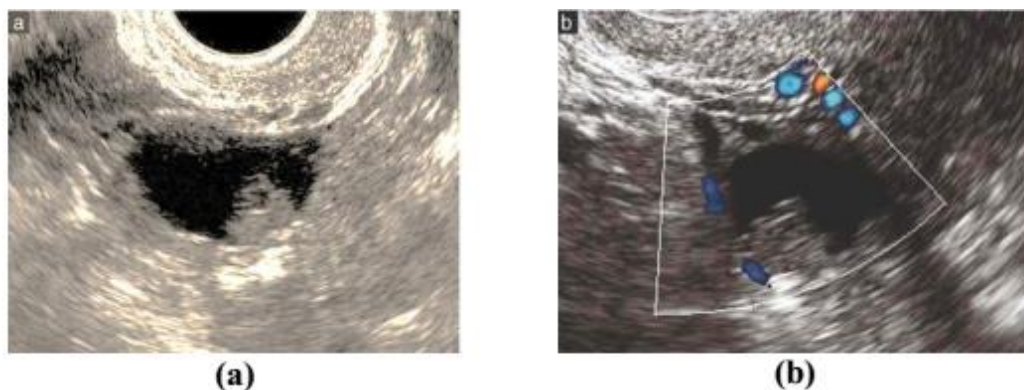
US images showing benign serous cystadenoma: (a) gray-scale image showing small cyst with internal papilla; (b) power Doppler imaging did not show internal vascularization of the papilla (20)
